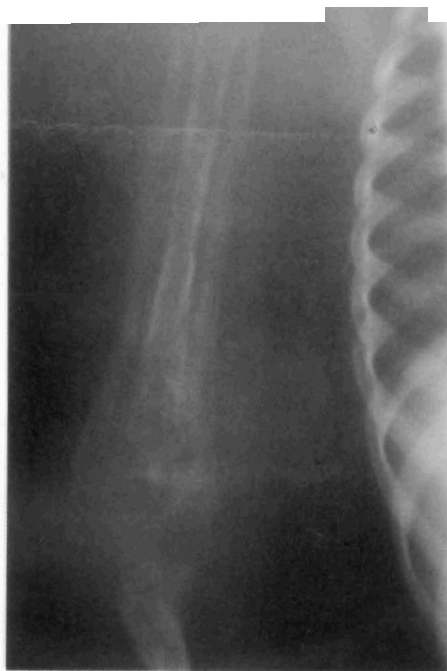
Radiograph showing sequestrum of the entire diaphysis of the humerus. It is common in Sickle Cell Disease to have this type of extensive disease process.
